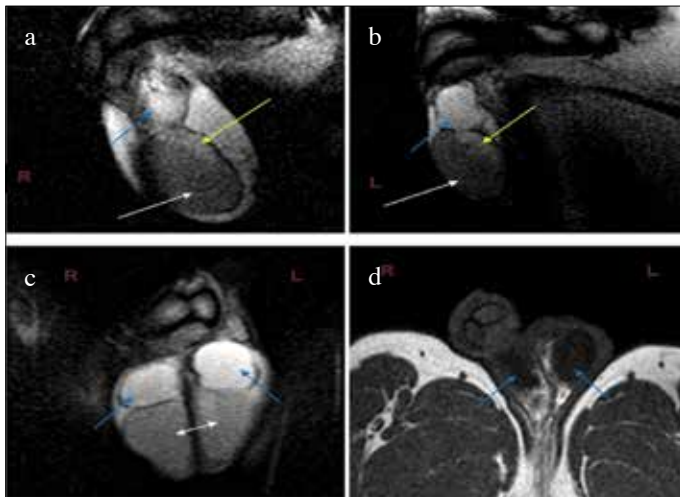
a-d. Scrotal MRI: normal testicular tissue (white arrows), epididymal cysts indicating peripheral hypointense, and hyperintense areas in T1AG, and T2AG (blue arrows) are observed, respectively. Besides at the level of testicular mediastinum, cystic dilations of rete testis indicating hypointense areas at T2AG (yellow arrows) are noticed
